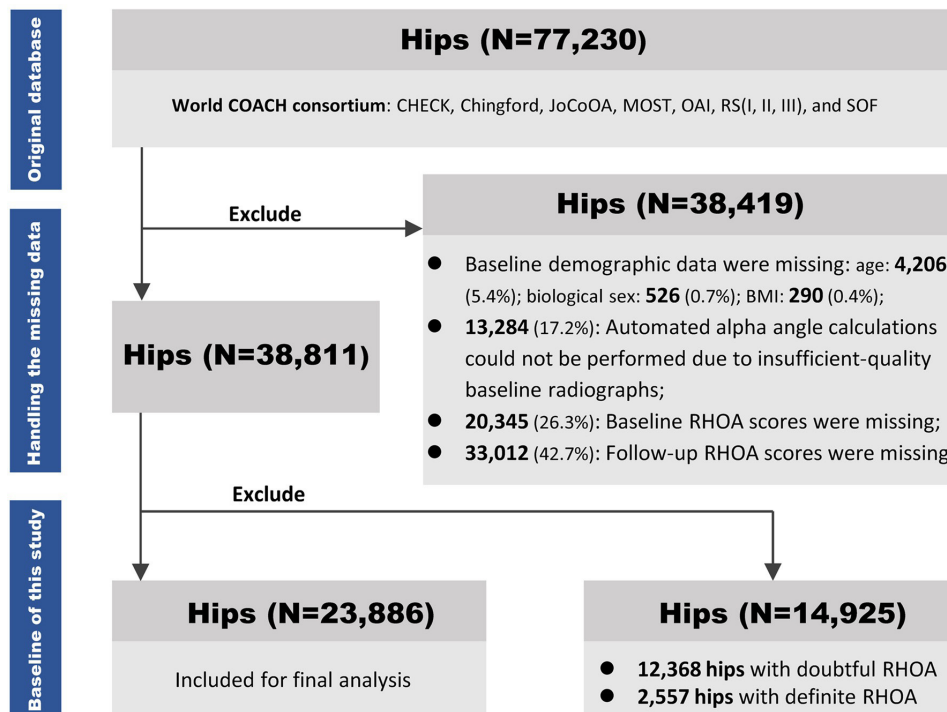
Complete flow of hips from the original dataset to the baseline of this study. BMI, body mass index; CHECK, Cohort Hip and Cohort Knee; JoCoOA, Johnston County Osteoarthritis Project; MOST, Multicentre Osteoarthritis Study; OAI, Osteoarthritis Initiative; RHOA, radiographic hip osteoarthritis; RS, Rotterdam Study; SOF, Study of Osteoporotic Fractures.
